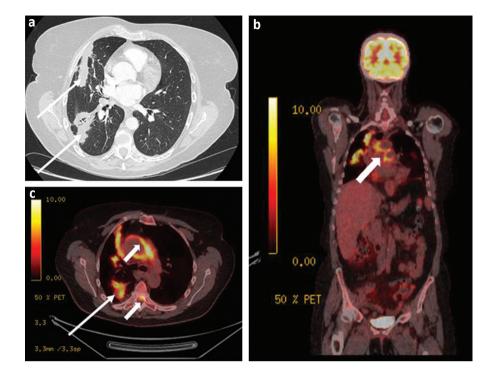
a) Axial computed tomography of the chest showing multifocal right lung lesions (longer arrows). b) and c) Computed tomography – positron emission tomography showing avid right lung lesion (longer arrows) and avid fluorodeoxyglucose uptake in the aortic arch, pulmonary trunk and thoracic dura (shorter arrows).
